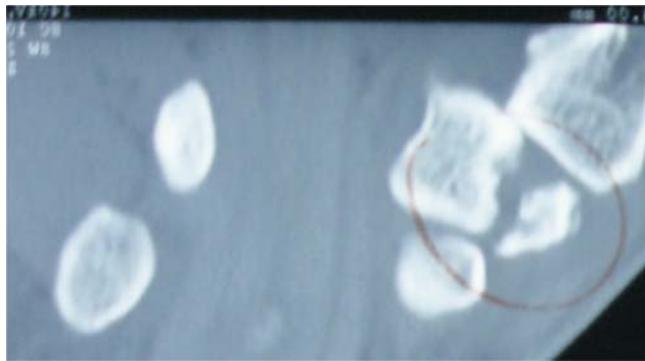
CT of the left hand showing old non-union fracture of the trapezium
